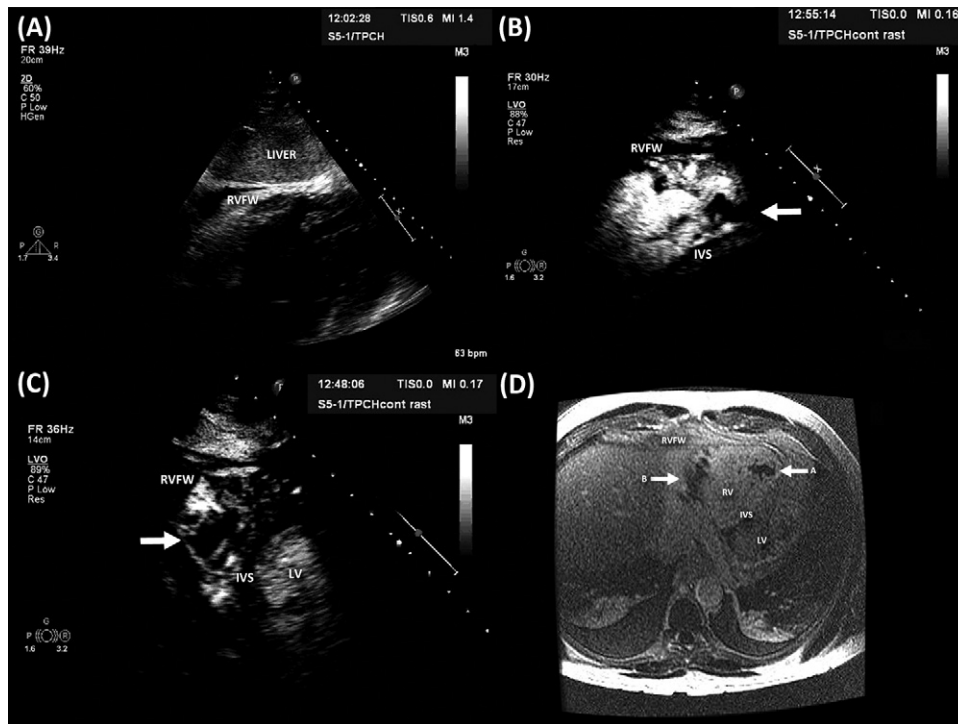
(A) Unenhanced transthoracic echocardiography, subcostal view, with no demonstration of right ventricular thrombus; (B) contrast-enhanced transthoracic echocardiography, subcostal long-axis view, clearly demonstrating the presence of an apical right ventricular thrombus; (C) contrast-enhanced transthoracic echocardiography, subcostal short-axis view, clearly demonstrating a right ventricular apical thrombus; (D) delayed gadolinium enhanced magnetic resonance imaging, four-chamber view, clearly demonstrating the presence of both right ventricular apical and basal free-wall thrombus. (Legends: thick arrow head = right ventricular thrombus; arrow head A = apical thrombus; arrow head B = basal free wall thrombus; IVS = interventricular septum; LV = left ventricle; RV = right ventricle; RVFW = right ventricular free wall.)
